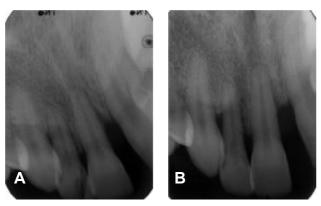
X-ray of the defect tooth 8, 9: A - at baseline; B - treated with PPT and enamel matrix proteins 3 years after.
